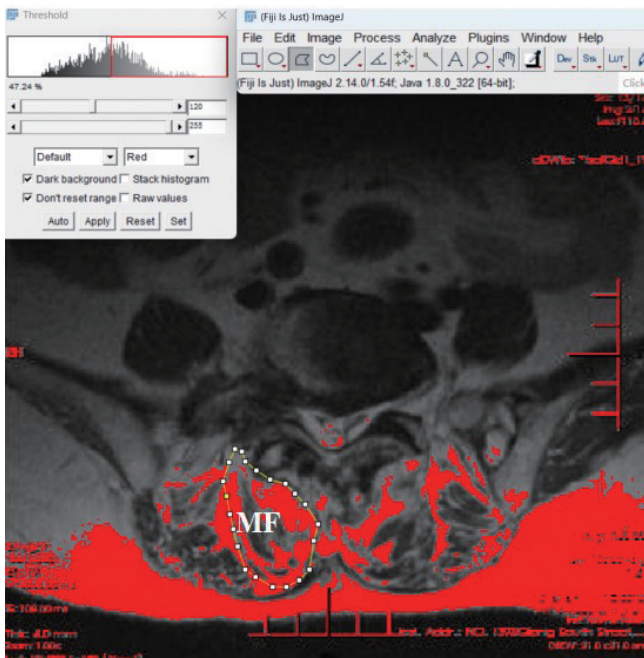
Measurement method of the MF FI. The Image J Threshold method on the middle layer of magnetic resonance image in each segment. Red pixels represent fat tissues. MF, multifidus muscle; FI, fatty infiltration.
